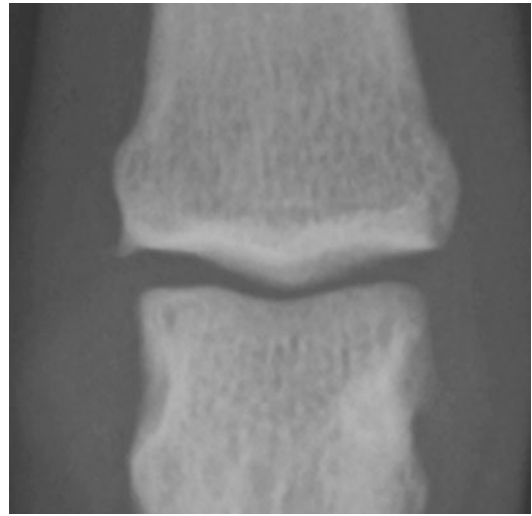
An a.p. X-ray of the ring finger of a male climber of the PIP joint (age, 32 years; climbing time, 12 years). Small osteophytes at the radial side of the PIP joint
